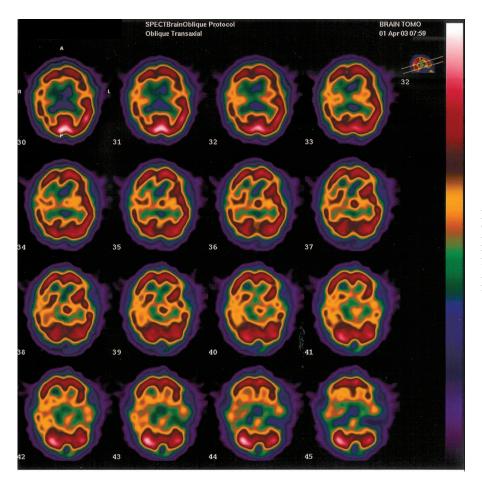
Single photon emission computed tomography (SPECT), brain oblique transaxial views showing hypoperfusion of the right parietal, temporal, and frontal cortex. The right thalamic region appears relatively hypoperfused compared to the contralateral portions.
